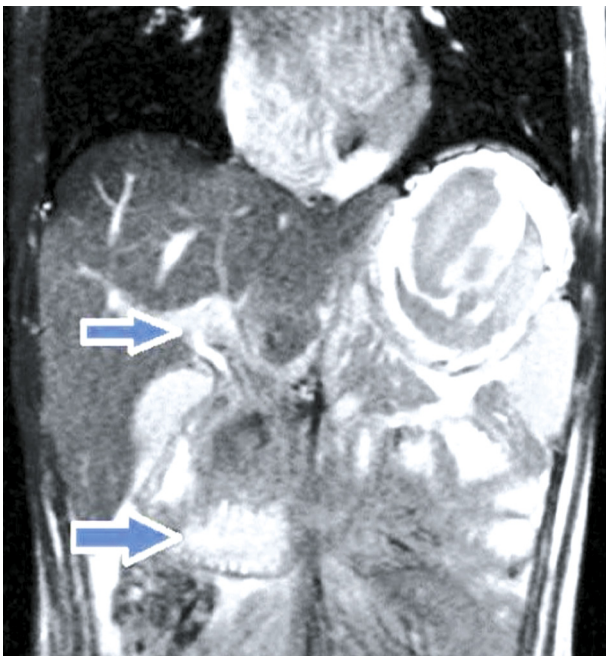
Abdominal MRI shows GDA aneurysm with contrast in the duodenum.
